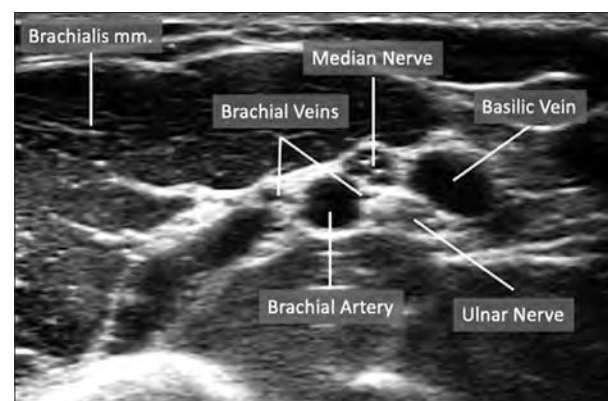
Transverse ultrasound view of the structures of the medial upper arm.
